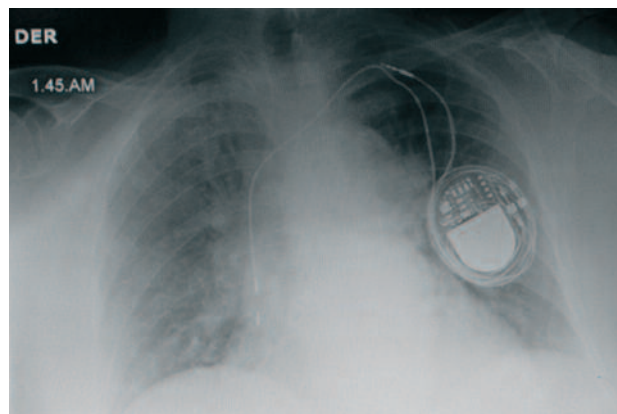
Chest x-ray showing atrial lead displacement and ventricular lead traction. Rotation of the generator in its transverse axis and rolling of leads around it (Reel syndrome) can also be observed.
